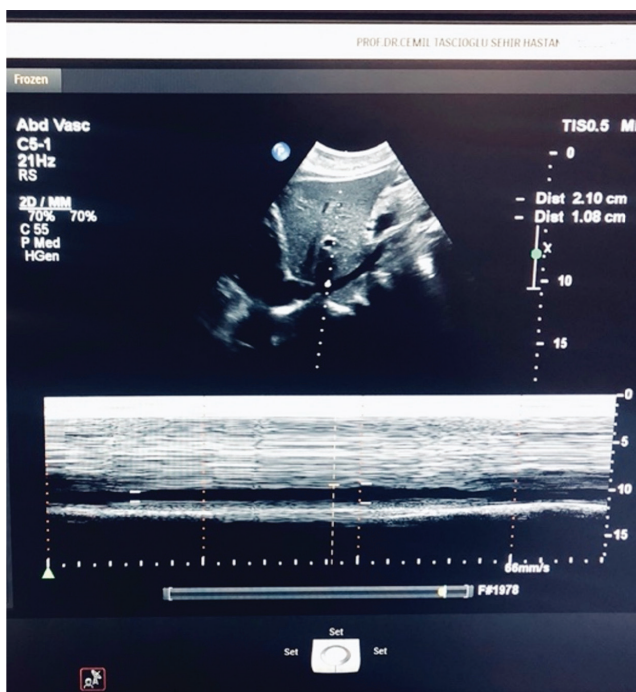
Diameter measurement of the inferior vena cava with M mode ultrasonography
